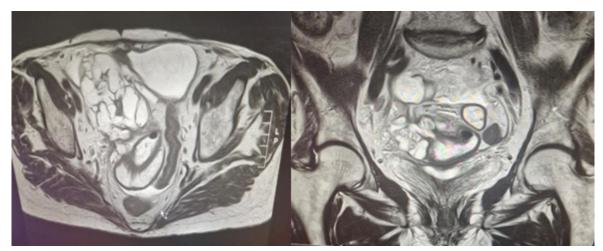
MRI scan indicating cystic pelvic tumor originating from the appendix, with a suspected fistulous connection.
